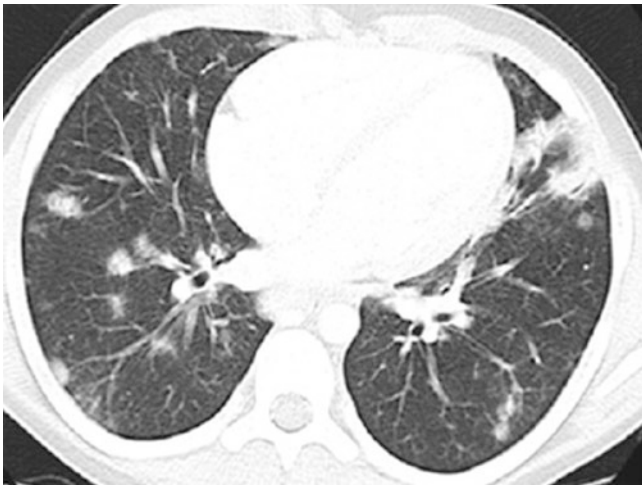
Bronchiolitis obliterans organizing pneumonia (BOOP): axial lung window CT image shows diffuse nodules with mild intra-lobular septal thickening and mild patchy ground glass opacifications consistent with BOOP
